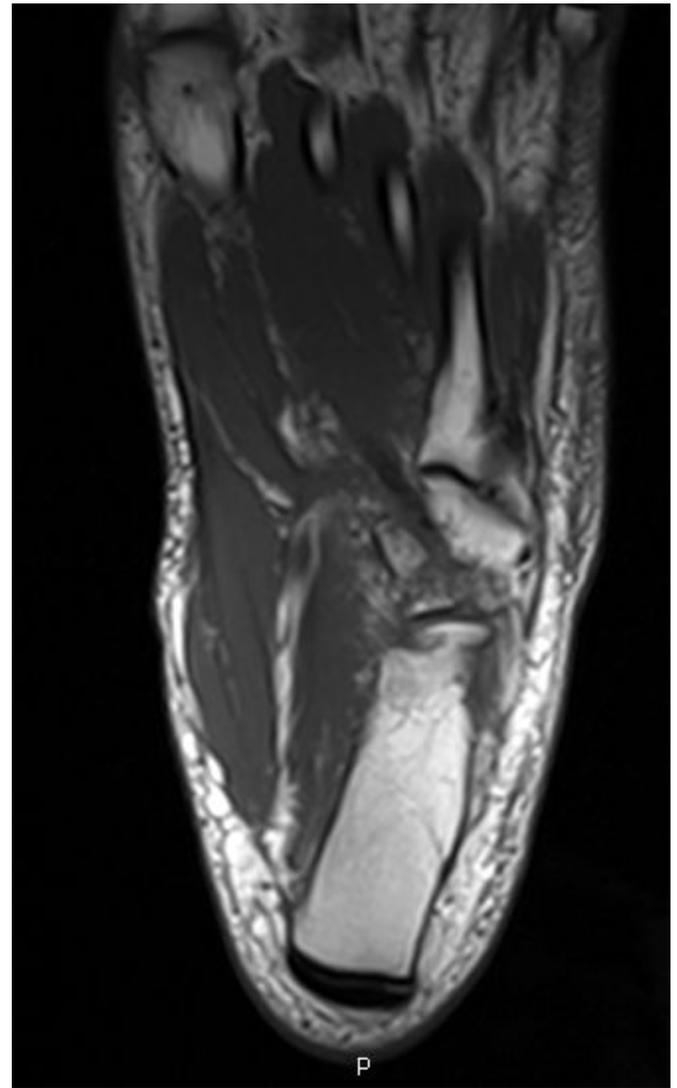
Axial MRI film revealing diffuse cuboid comminution and interposed peroneus longus tendon.
